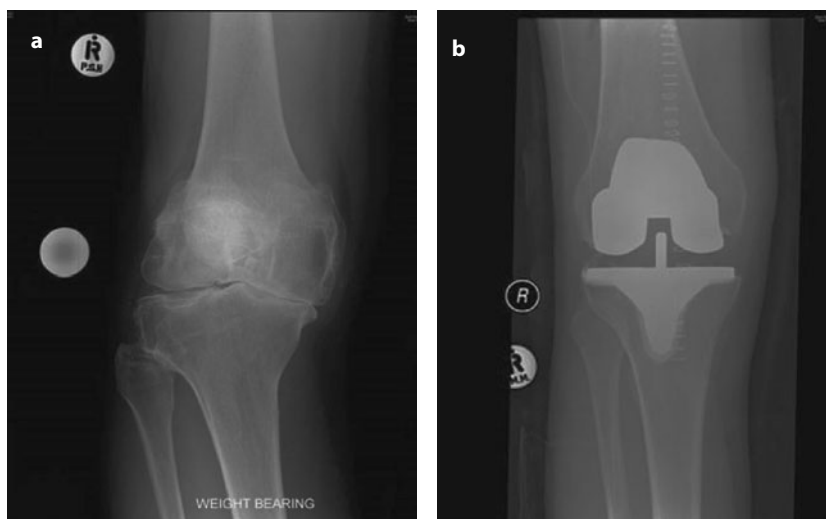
a, b Pre and post-operative radiographs showing tricompartmental arthritis and good clinical result with a total knee replacement
